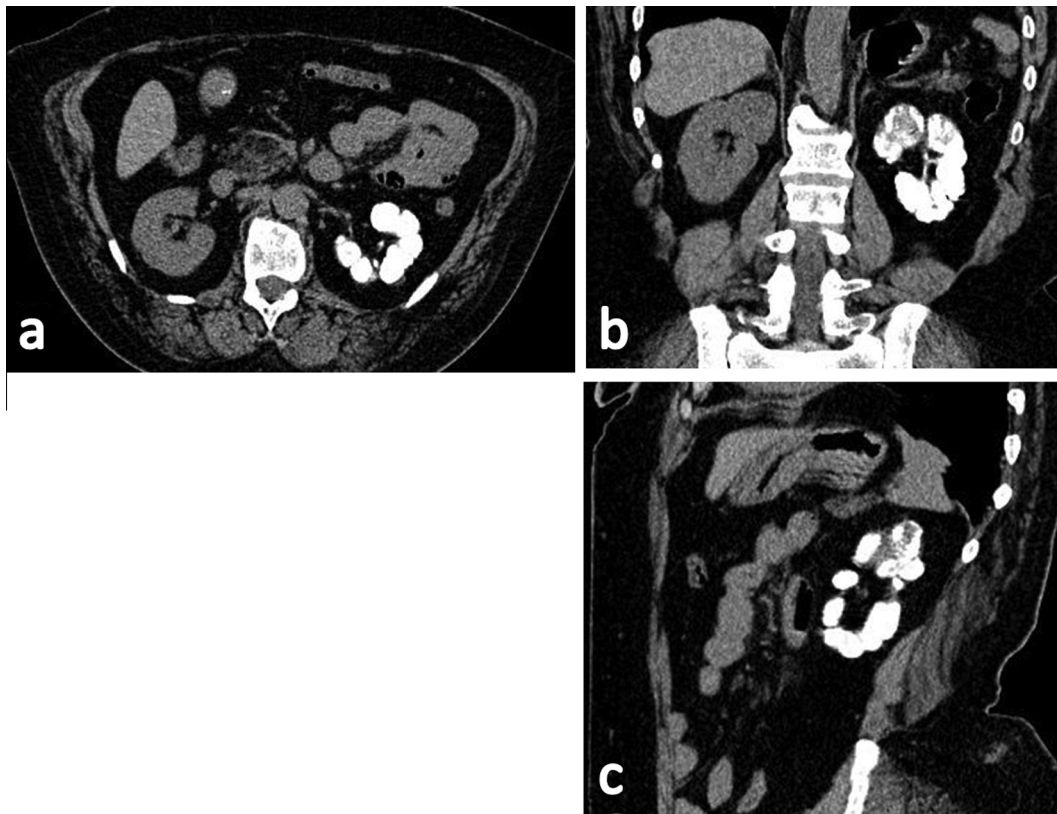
Sixty-eight year old female patient with left flank pain. CT stone protocol through the left kidney in (a) axial, (b) coronal, and (c) sagittal planes revealed a small calcified left kidney, consistent with putty kidney.
